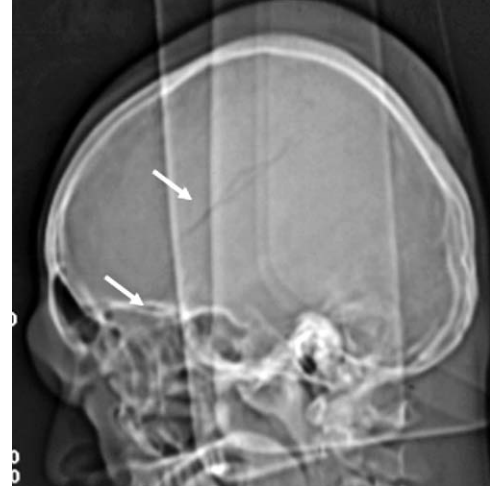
CT scan tomogram showing linear fracture of temporal and parietal bones (arrows)
